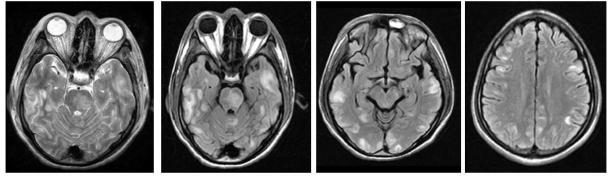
T2 & FLAIR hyperintenisties in pons, bilateral frontal, temporal, parietal and occipital regions – s/o demyelination
